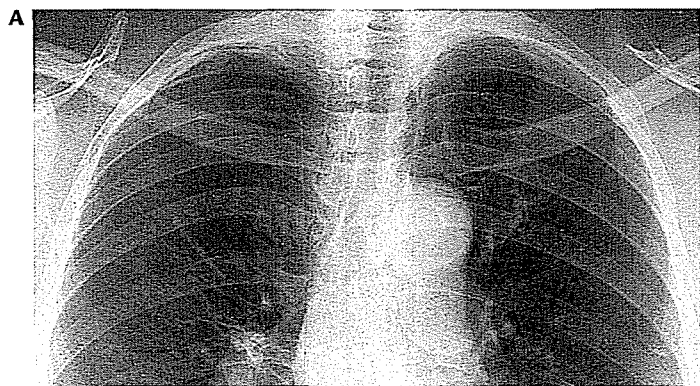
Apical pleural scar. A, Chest radiograph shows asymmetric soft tissue thickening at the right apex. B and C, CT shows irregular subpleural density, with spiculation mimicking lung cancer. The patient was followed for 2 years without evidence of progression.
